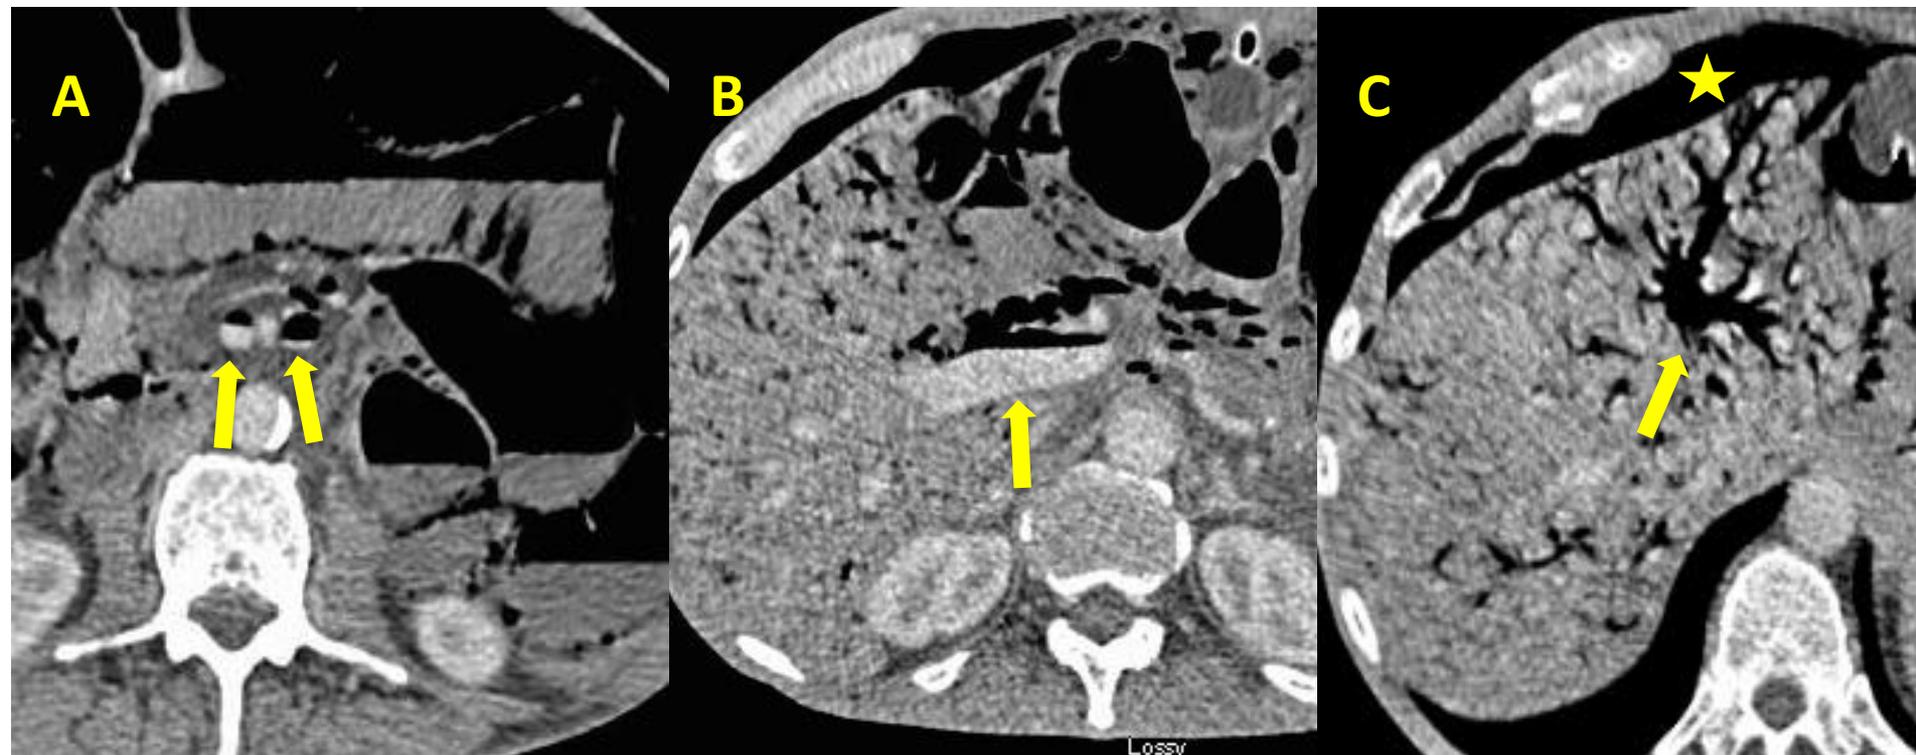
Portomesenteric venous gas on portal venous phase CT abdomen. (A) Air within the superior (left) and inferior (right) mesenteric veins. (B) Air within the main portal vein. (C) Air in the biliary tree with a pneumoperitoneum (*).
